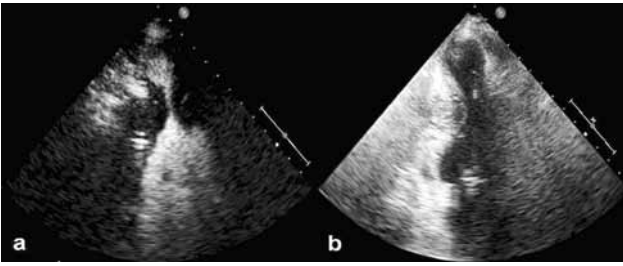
Transthoracic echocardiography with (a) and without (b) contrast showing mid-ventricular obstruction and an apical aneurysm.
